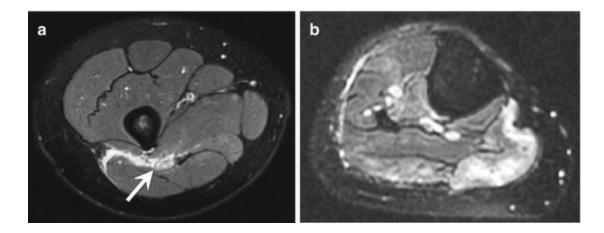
A 26-year-old woman with an iatrogenic sciatic nerve injury due to a nerve block and resultant permanent residual deficits. (a) Axial fat-suppressed T2-weighted MRI shows an enlargement of the sciatic nerve (arrow) surrounded by soft tissue edema. (b) Axial fat-suppressed T2-weighted MRI of the calf shows patchy muscle edema mostly affecting the gastrocnemius muscles
